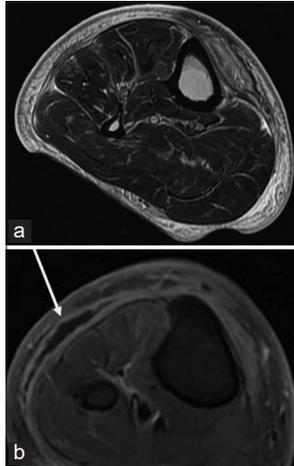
Axial T2-weighted magnetic resonance (a) demonstrating increased T2 signal throughout the subcutaneous fat and perifascial edema in keeping with cellulitis, a focal rim enhancing collection (white arrow) is seen in the post-contrast T1 FS axial image (b) represents a subcutaneous abscess. No air seen to suggest necrotizing fasciitis.
